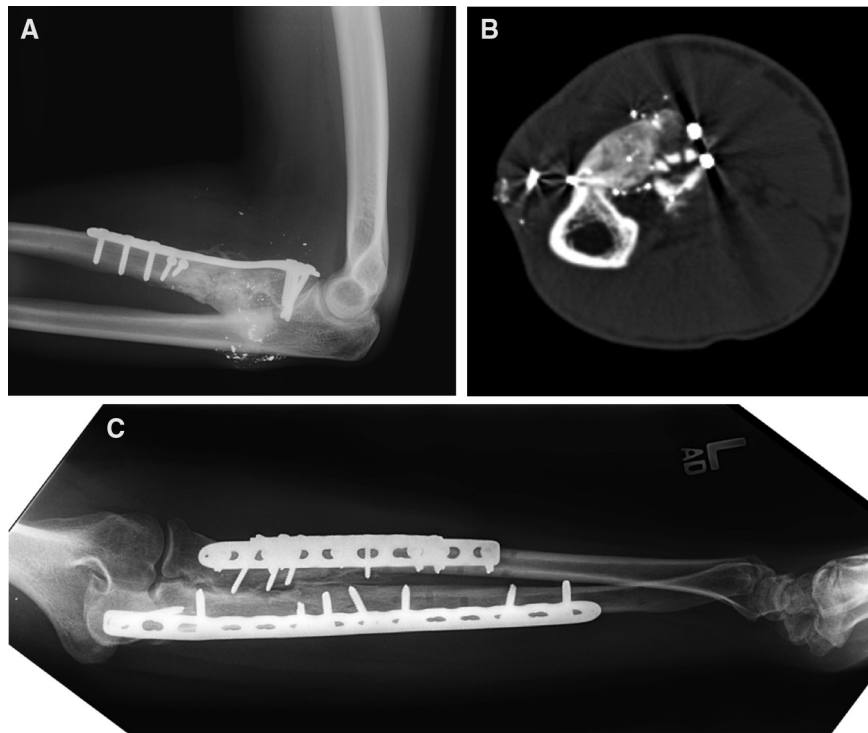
(A) Lateral radiograph and (B) axial computed tomography slice of a patient who developed a complete synostosis after a gunshot wound and subsequent surgical fixation. (C) Forearm radiograph of a patient with extensive proximal radioulnar synostosis extending near the mid-diaphysis.
